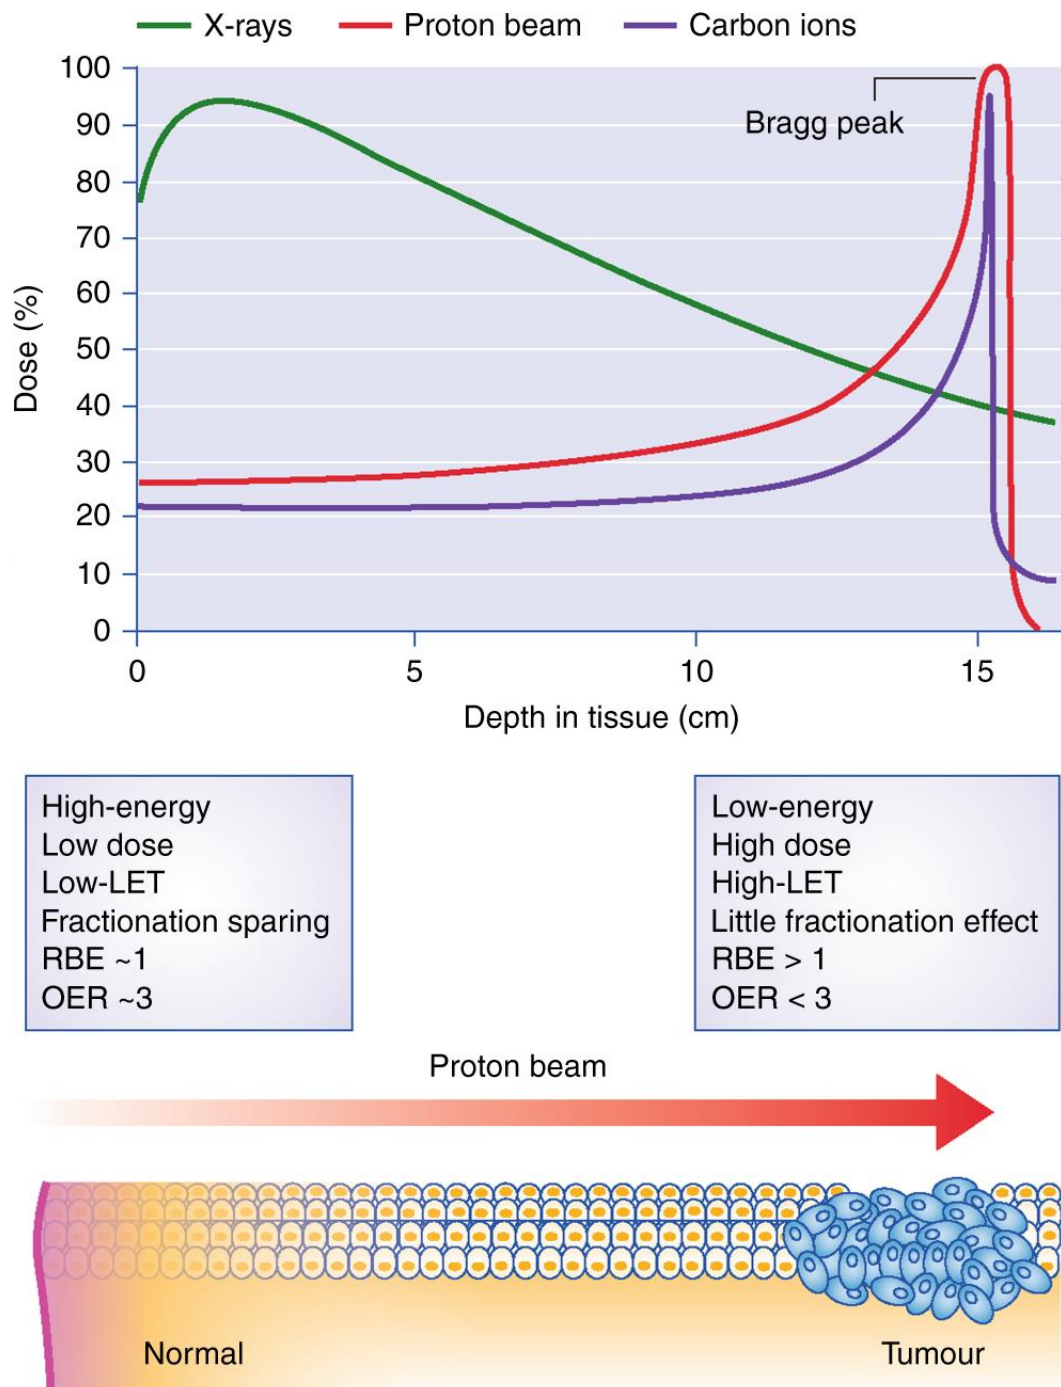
In Hadron therapy, a suitable depth-dose curve is used. While the charged particles transfer most of their energy near the region where they slow down at the end of the tumor target (Bragg peak), the X-ray energy decreases exponentially with the dose. For high energetic particles, LET rises around the Bragg peak. This provides radiobiological advantages such as state biological efficacy (RBE) and reduced oxygen enhancement rate (OER) (Durante, 2018).
